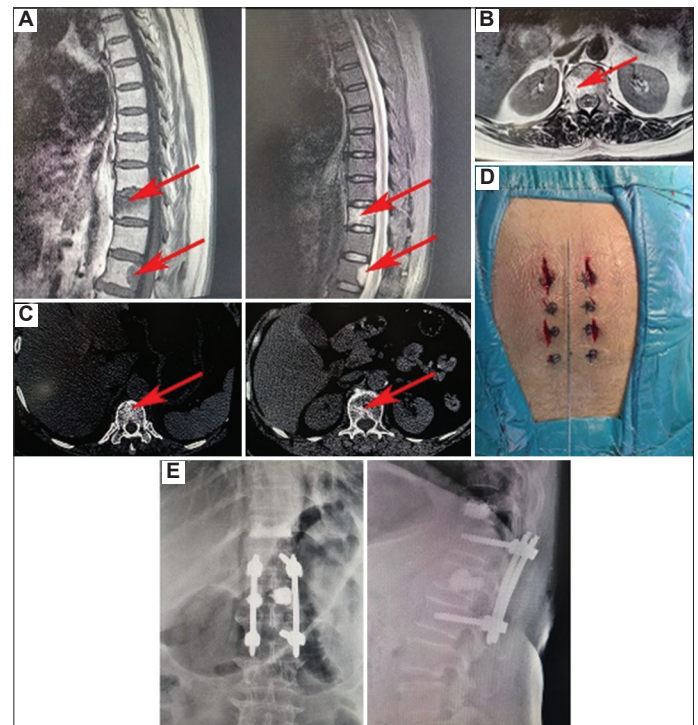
(A) Sagittal magnetic resonance imaging (MRI) shows a significant vertebral mass in T11 and L1, which was due to cancer metastasis in a 67-year-old woman. (B) Axial MRI shows a significant vertebral mass in L1. (C) Axial computed tomography shows lesions in the T11 and L1 vertebral bodies. (D) The picture shows the size of the wound after the operation. (E) Frontal and lateral views of the post-operative radiographs (Case 6).
